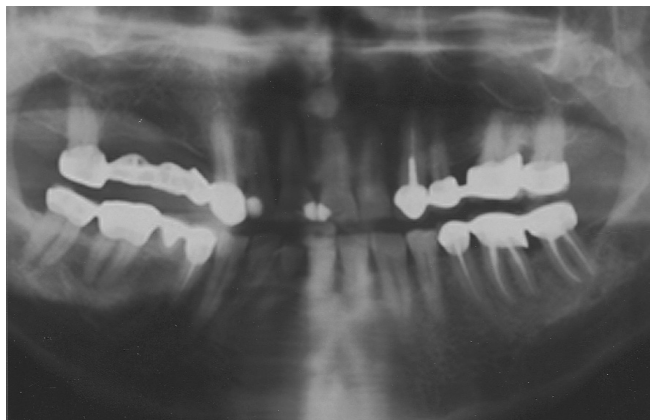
Panoramic radiograph of the jaw
